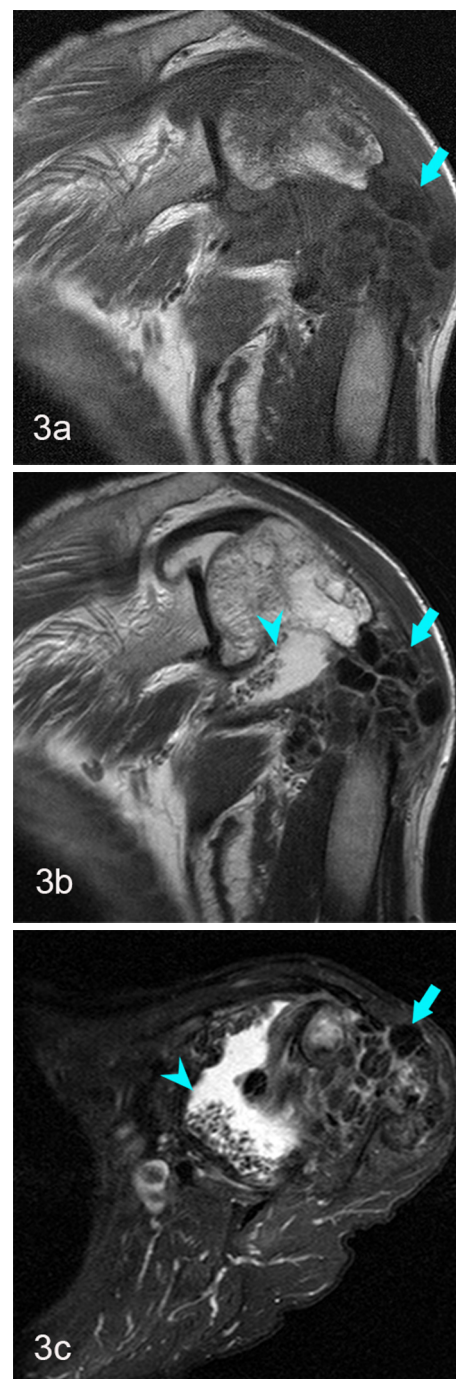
(A) Coronal T1-weighted (TR533/TE17), (B) coronal T2-weighted (TR2500/TE70), and (C) axial T2-weighted with fat saturation (TR3186/TE70) sequences (b) of the left shoulder demonstrate a large mass with low T1 and T2 signal (arrows) corresponding to mineralized areas on the prior radiograph. A large joint effusion with proliferative synovitis is also present (arrowheads).
